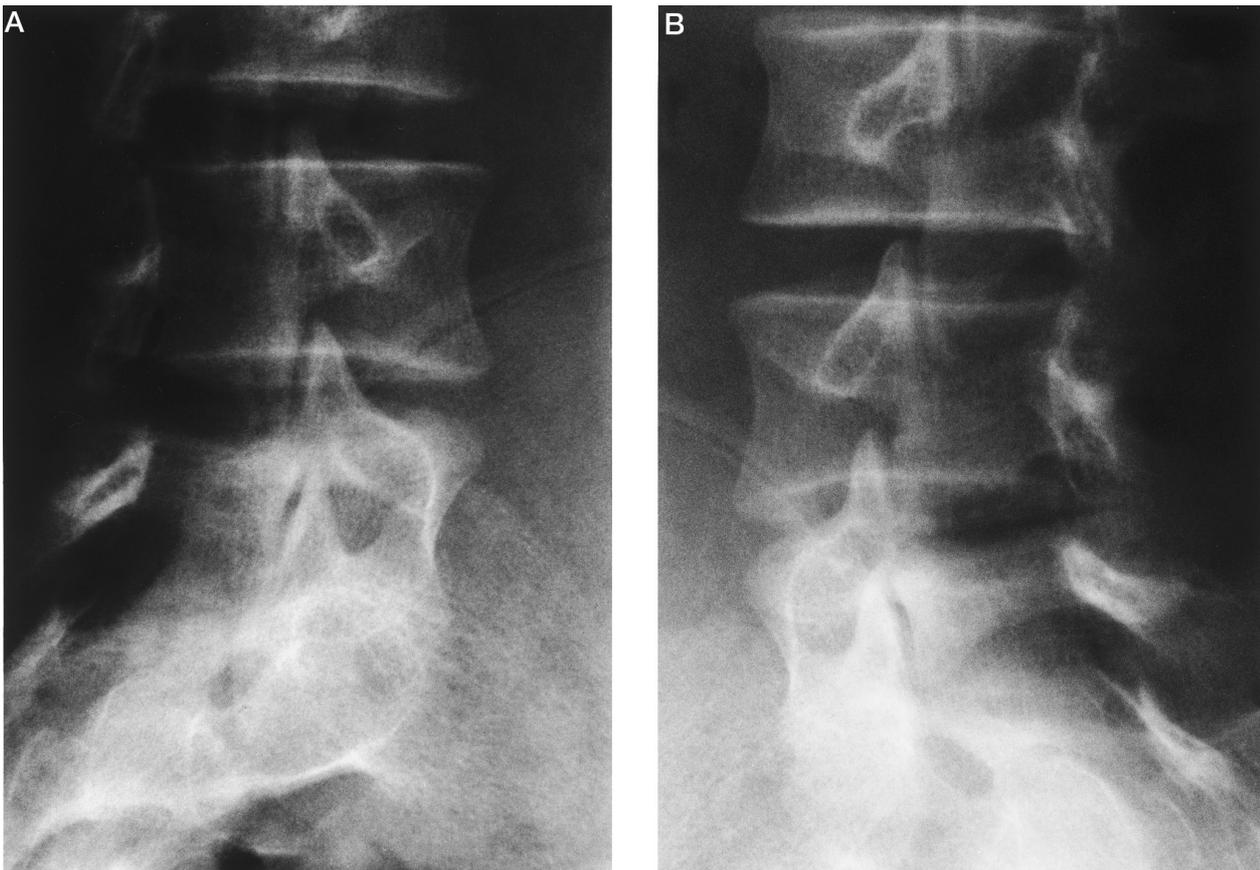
A and B, Conventional radiographs: lumbar obliques. Observe the bilateral pars defects at the L5 vertebra. *Comment:* This 16-year-old athlete complains of sharp lumbosacral pain. Are these lesions active or inactive? What tests will help us determine this?
